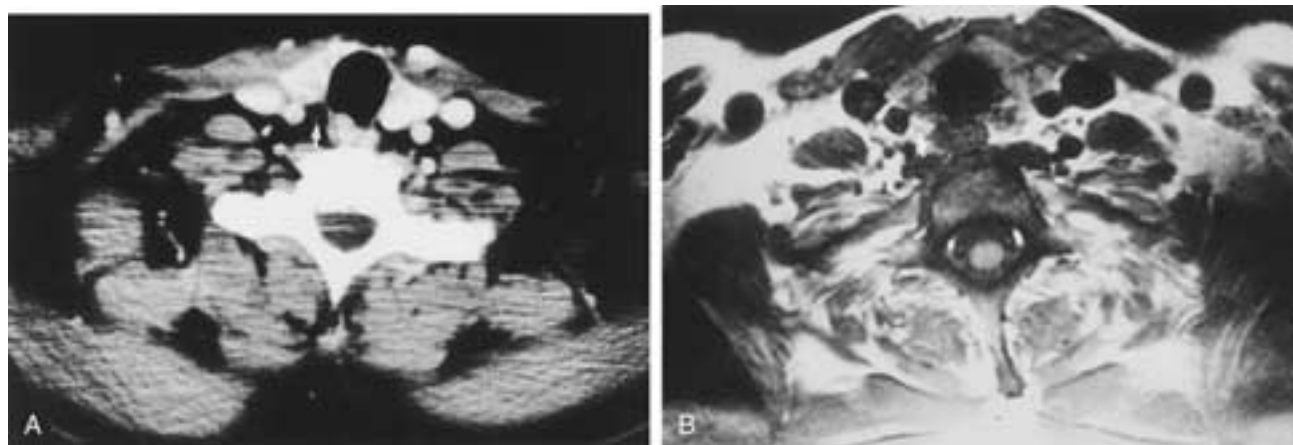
Recurrent laryngeal nerve—tracheoesophageal sulcus. Axial CT scan (A) and T1-weighted MR image (B) show the right recurrent laryngeal nerve in the tracheoesophageal sulcus (arrow).
